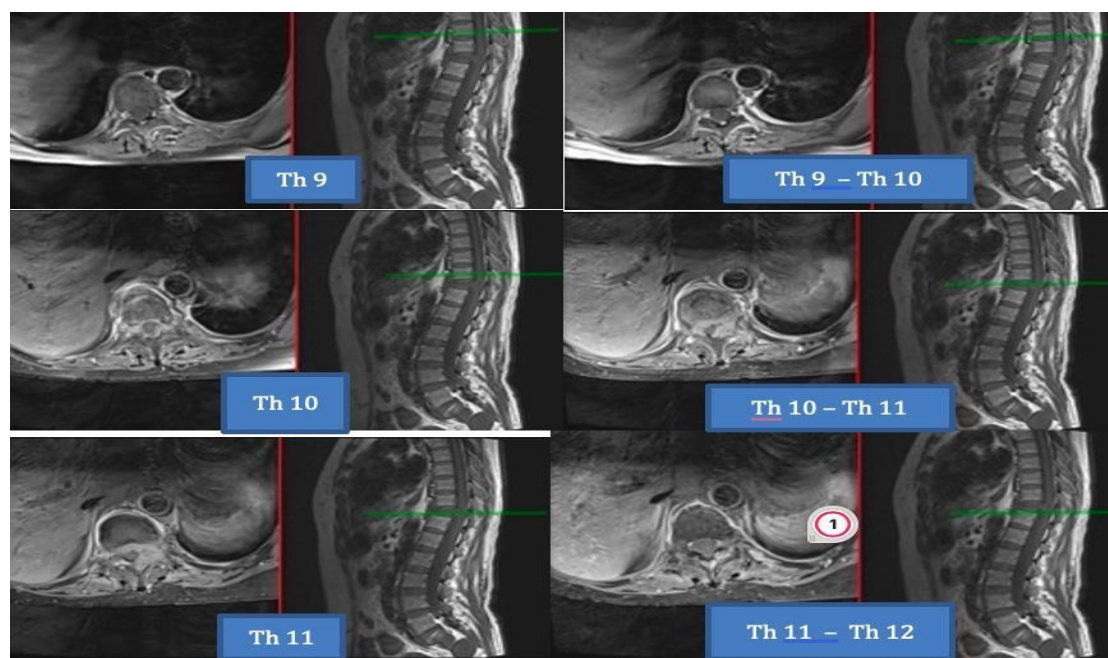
T1 W Axial view of MRI
